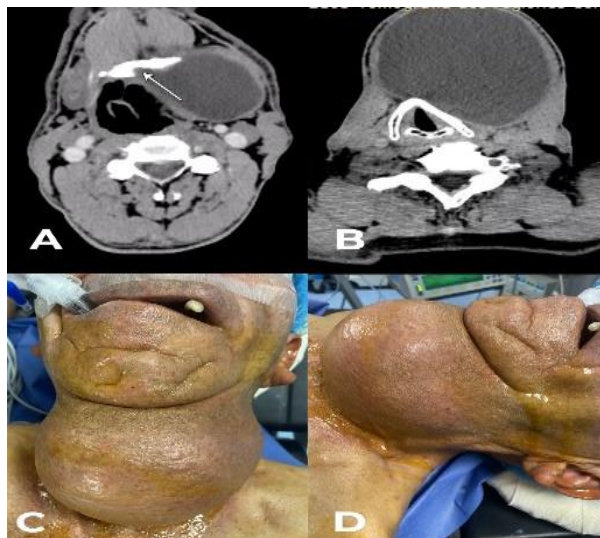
(A-D): Computed tomography shows thyroglossal cyst clearly in relation to hyoid bone, as indicated by the arrow. CT reveals large size of thyroglossal cyst. Preop frontal view of thyroglossal cyst. Lateral view of the thyroglossal cyst.
